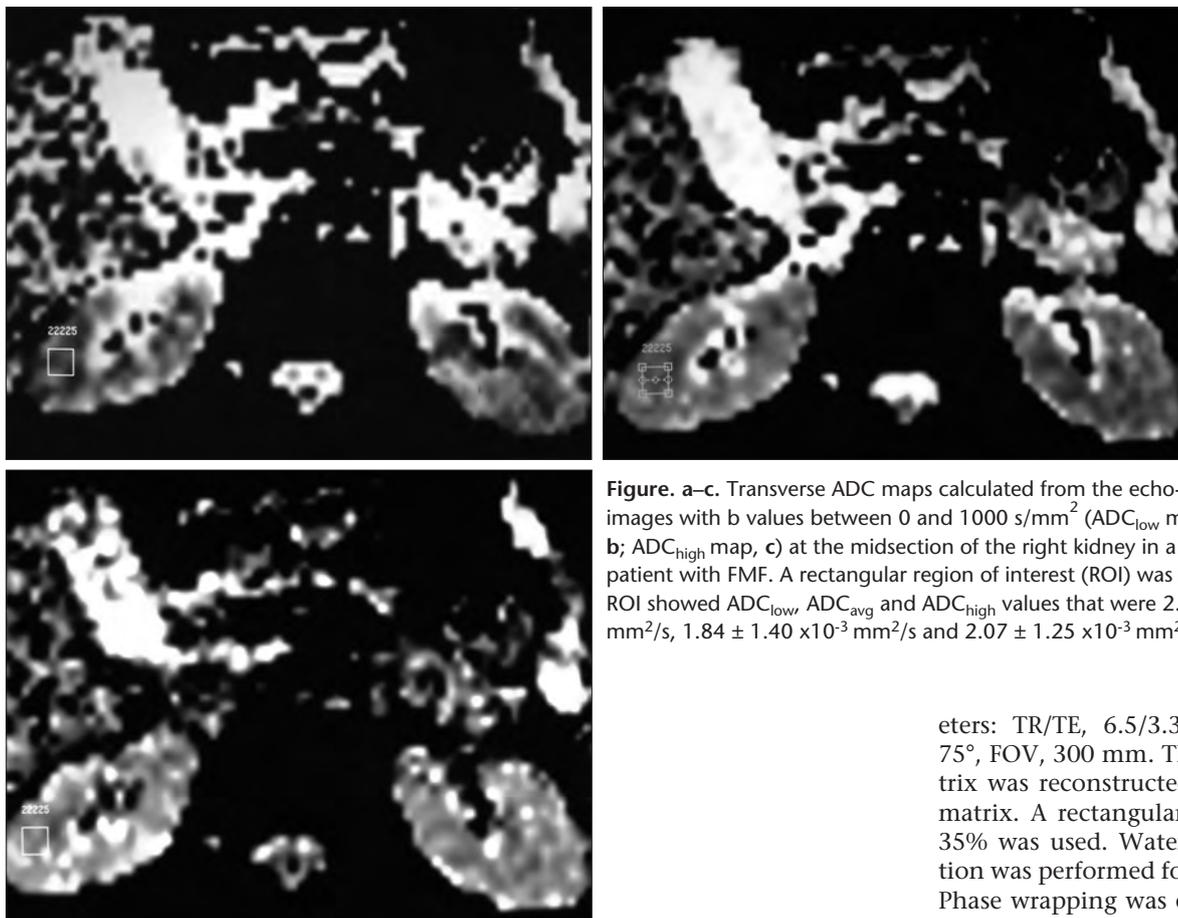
a–c. Transverse ADC maps calculated from the echo-planar DW-MR images with b values between 0 and 1000 s/mm² (ADC_{low} map, a; ADC_{avg} map, b; ADC_{high} map, c) at the midsection of the right kidney in a 21-year-old female patient with FMF. A rectangular region of interest (ROI) was placed in the cortex. ROI showed ADC_{low}, ADC_{avg} and ADC_{high} values that were $2.22 \pm 1.24 \times 10^{-3}$ mm²/s, $1.84 \pm 1.40 \times 10^{-3}$ mm²/s and $2.07 \pm 1.25 \times 10^{-3}$ mm²/s, respectively.
